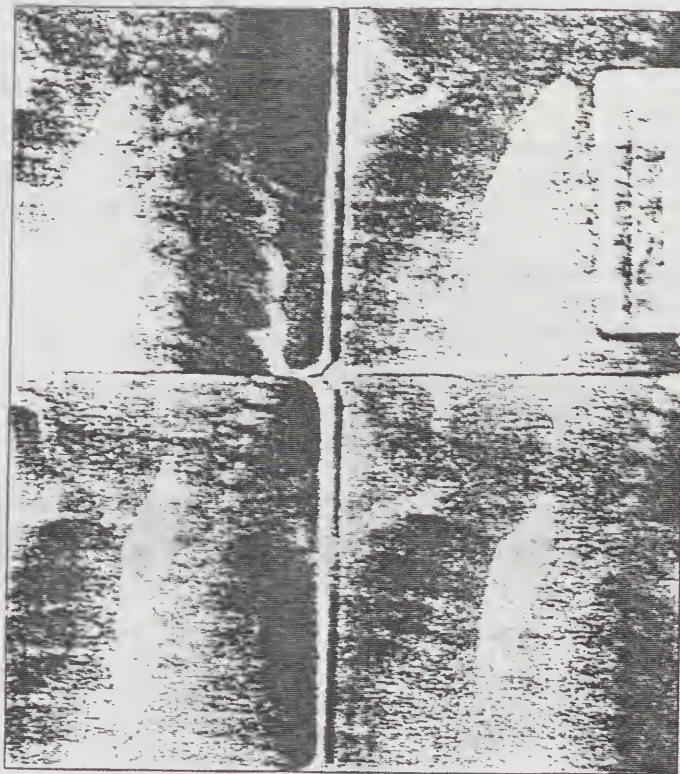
Characteristic radiographic impression of a right Aberrant Subclavian Artery. On the frontal view the esophageal indentation runs obliquely upward and to the right.
